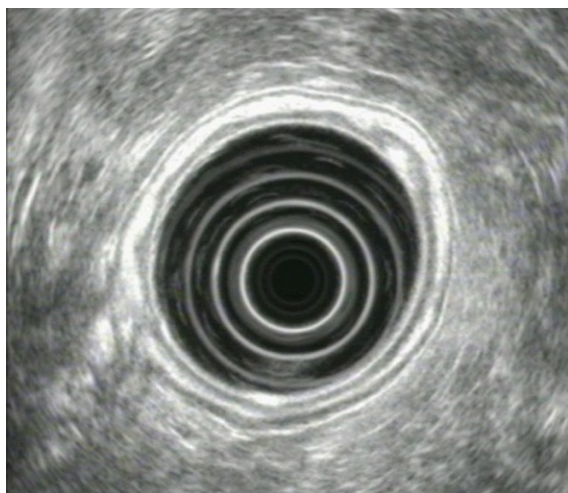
Gastric endoscopic ultrasonography. Note the 5 distinct layers that comprise the gastric wall.
